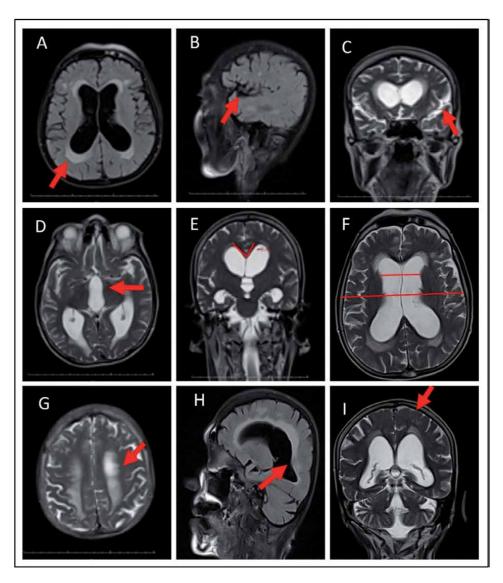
MRI images of NPH a: Periventricular hyperintensity, B: Enlargement of Sylvian cistern (sagittal), C: Enlargement of Sylvian cistern (coronal), D: Dilatation in the third ventricle, E: Callosal angle, F: Evans index, G: Hyperintensity in white matter, H: Bulging on the roof of the ventricle, I: Effacement of sulci at midline vertex.
